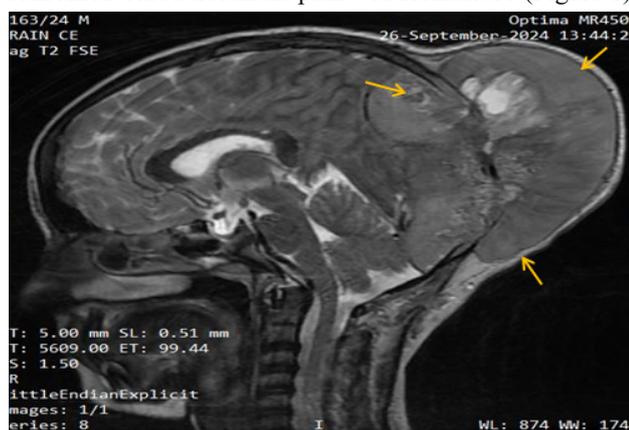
MRI of the brain shows an abnormal signal intensity mass lesion centered over the occipital region, producing a significant bulge in the overlying skin. The lesion causes erosion of the underlying occipital bone with intracranial extension into the posterior parietal and occipital regions, exerting extrinsic compression on the superior surface of the cerebellum.
